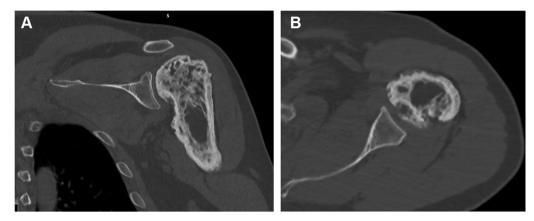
Representative preoperative coronal (A) and axial (B) CT scan images demonstrating Paget's disease isolated to the left humerus as well as bipolar articular irregularities.
